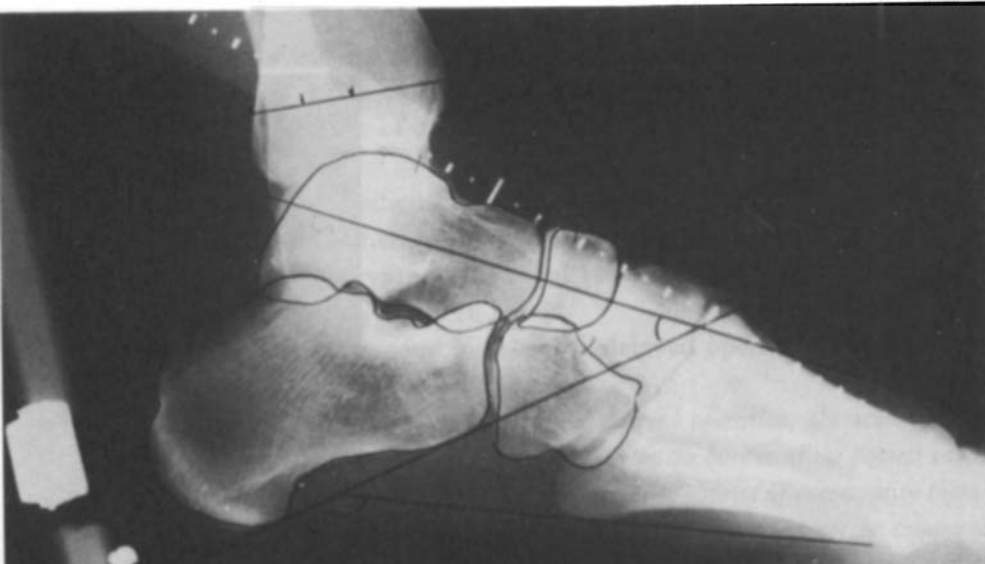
A lateral radiograph.
